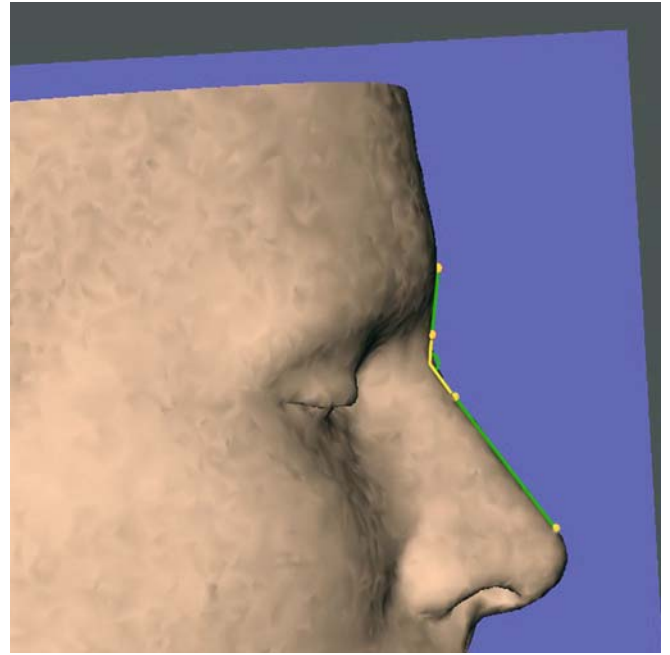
The nasofrontal angle, $g-se$ / nasal root tangent, is a projected angular soft tissue measurement on the median (z) 3-D cephalometric reference plane. The nasal root tangent is defined by a proximal and distal point on the midline of the nasal root (3-D CT, soft tissues, patient K.C.)
